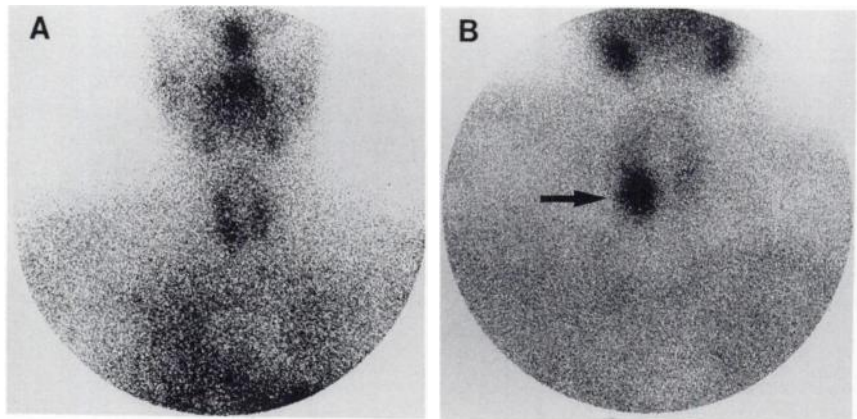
(A) Thallium-201 cervico-thoracic scintigraphy showing a relatively uniform thyroid uptake except for a slight asymmetry in the right lower neck (which was considered as being within normal range on $^{201}\text{Tl}/[^{99m}\text{Tc}]$ per technetate dual radiotracer scintigraphy). (B) A delayed ^{99m}Tc -sestamibi parathyroid imaging was obtained 3 days later and showed a significant lesion at the same level (arrow). Surgery revealed a right lower neck parathyroid adenoma (2.0 g).
